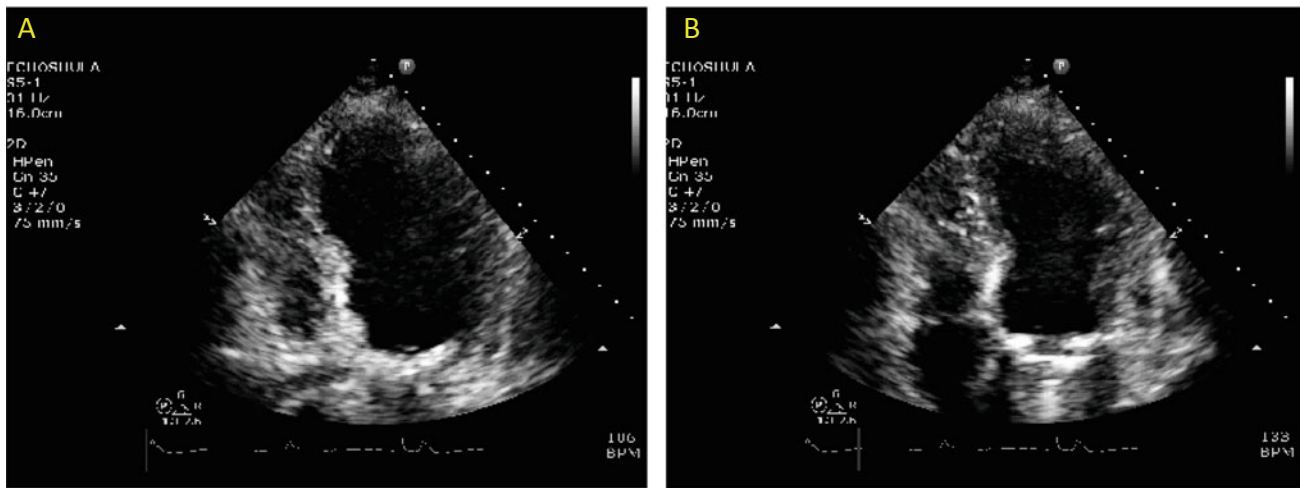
Still frames from echocardiogram performed at presentation. a Diastolic image, b Systolic image. There is a large regional wall motion abnormality with depression of the ejection fraction
